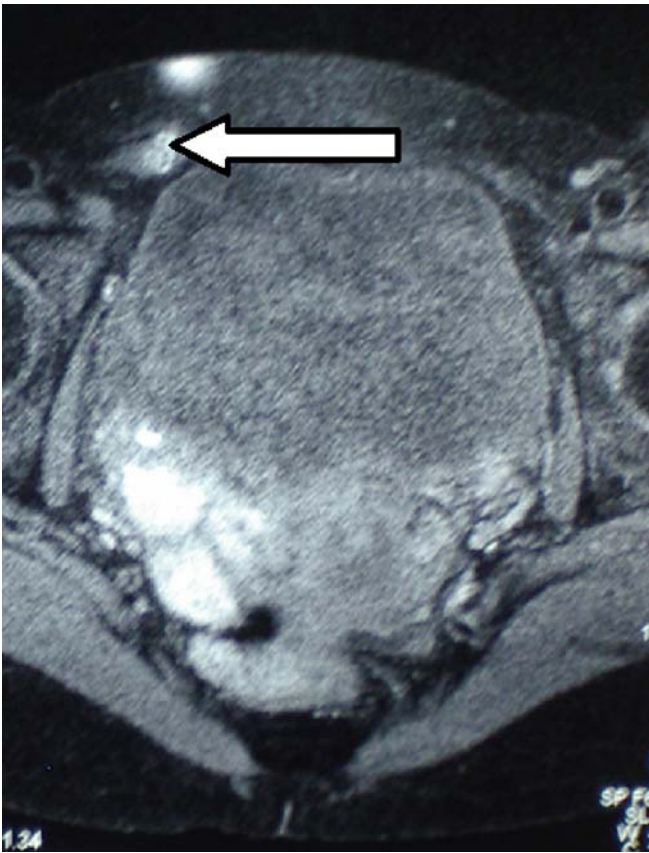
Pelvic T1 magnetic resonance image (MRI) with fat suppression sequence, axial slice showing endometriosis of the right round ligament (*white arrow*)
